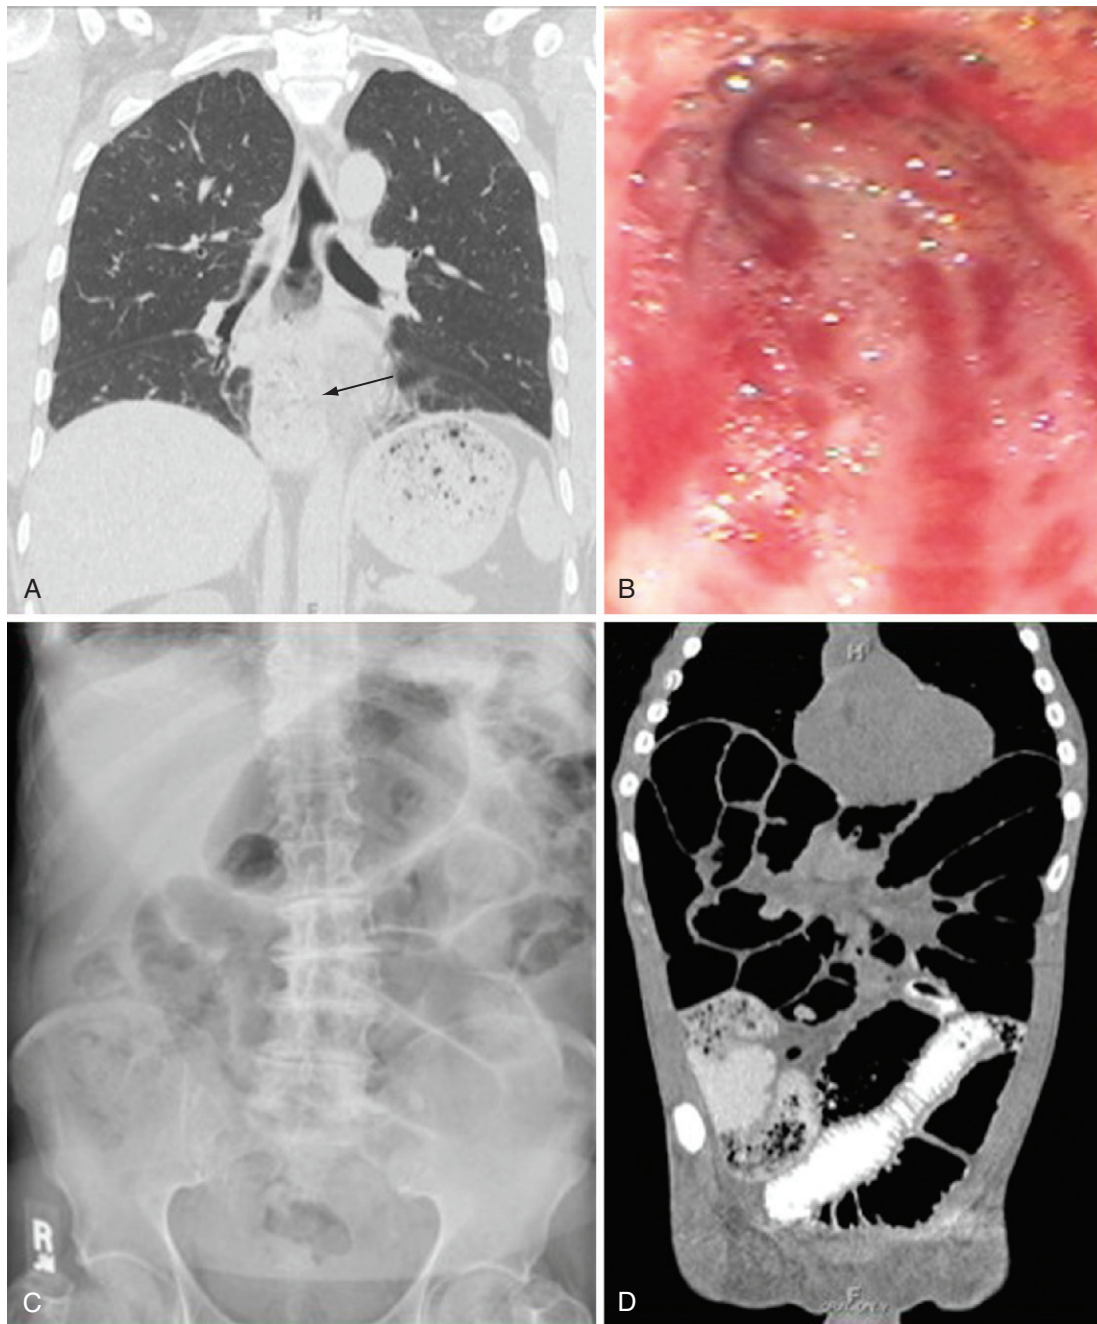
Gastrointestinal manifestations in scleroderma. A, Chest computed tomography (CT) (sagittal view) showing severe esophageal dysmotility with dilation and (arrow) retention of gastric content. B, Upper endoscopy: gastric antral vascular ectasias presenting as “watermelon” stomach. C and D, Plain abdominal x-ray and abdominal CT: small intestinal dysmotility with pseudo-obstruction, pneumatosis cystoides intestinalis.
